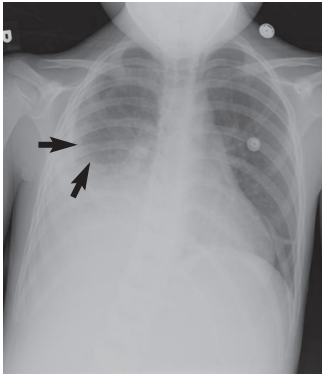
Upright chest radiograph of a 7-year-old child with a large pleural effusion on the right. The bottom third of the right hemithorax is white with a rounded superior margin (meniscus sign, *arrows*). The diaphragm is obscured, and there are air bronchograms in the right lower lung zone. This parapneumonic effusion was an empyema caused by streptococcal pneumonia.
